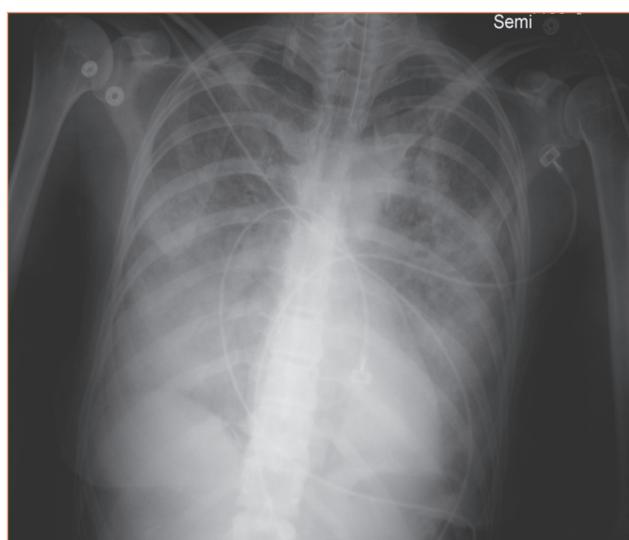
Chest Radiograph Obtained 30 Minutes Postoperatively
